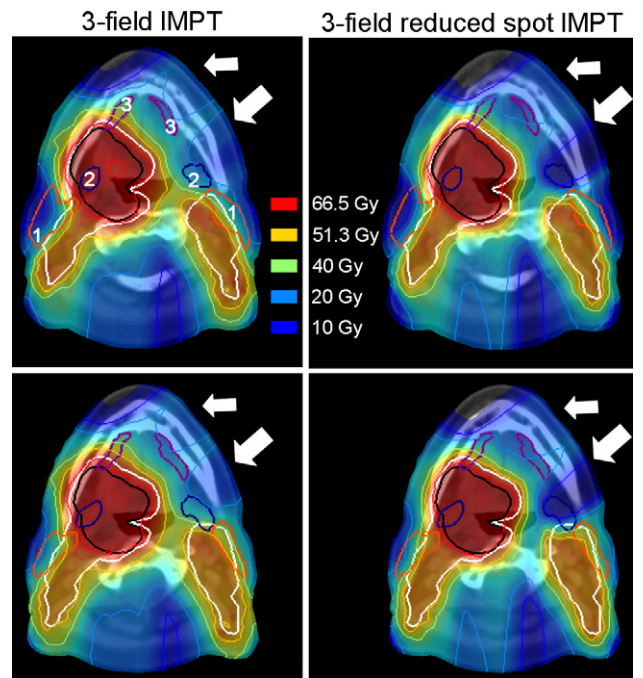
Dose distribution for both intensity-modulated proton therapy (IMPT) plans in Case 2 for two subsequent CT slices. Thick lines indicate the volumes of interest: elective planning target volume, PTV1 (white); boost volume PTV2 (black); parotid glands (1); submandibular glands (2); and sublingual glands (3). Arrows indicate the most important differences.
